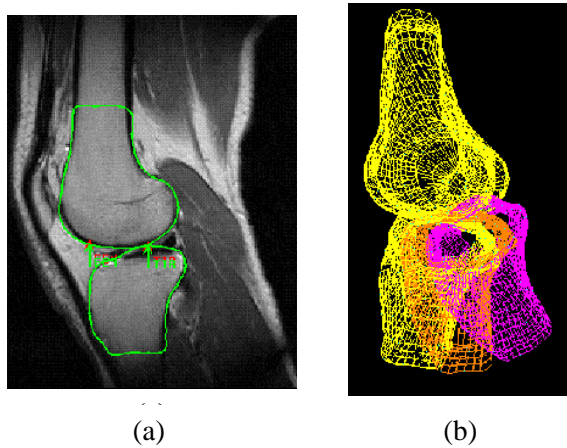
MRI of a knee in vivo (a) and geometrical reconstruction of the knee for different flexion (b).
